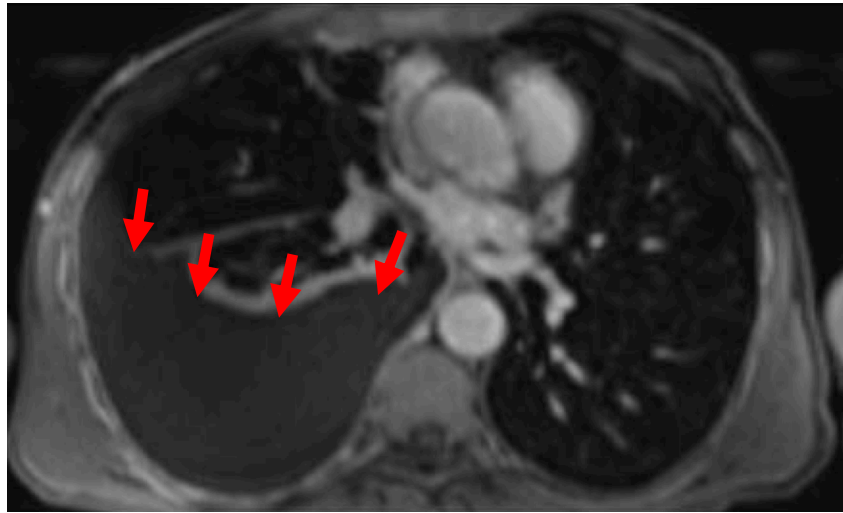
T1-weighted axial image of a patient with a right pleural effusion (indicated by arrows), taken post-contrast using a 3T Siemens Magnetom PRISMA® MR scanner at the Glasgow Clinical Research Imaging Facility, QEUH
